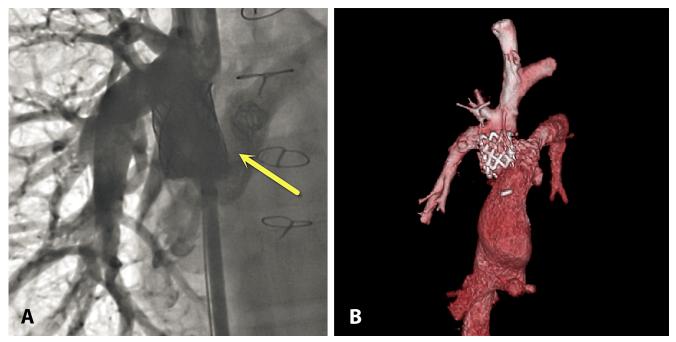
Panel A. Post-procedure angiogram, and Panel B. Follow-up computed tomography scan confirm widely patent Glenn and Fontan anastomoses connected by the 28 mm CP stent.
